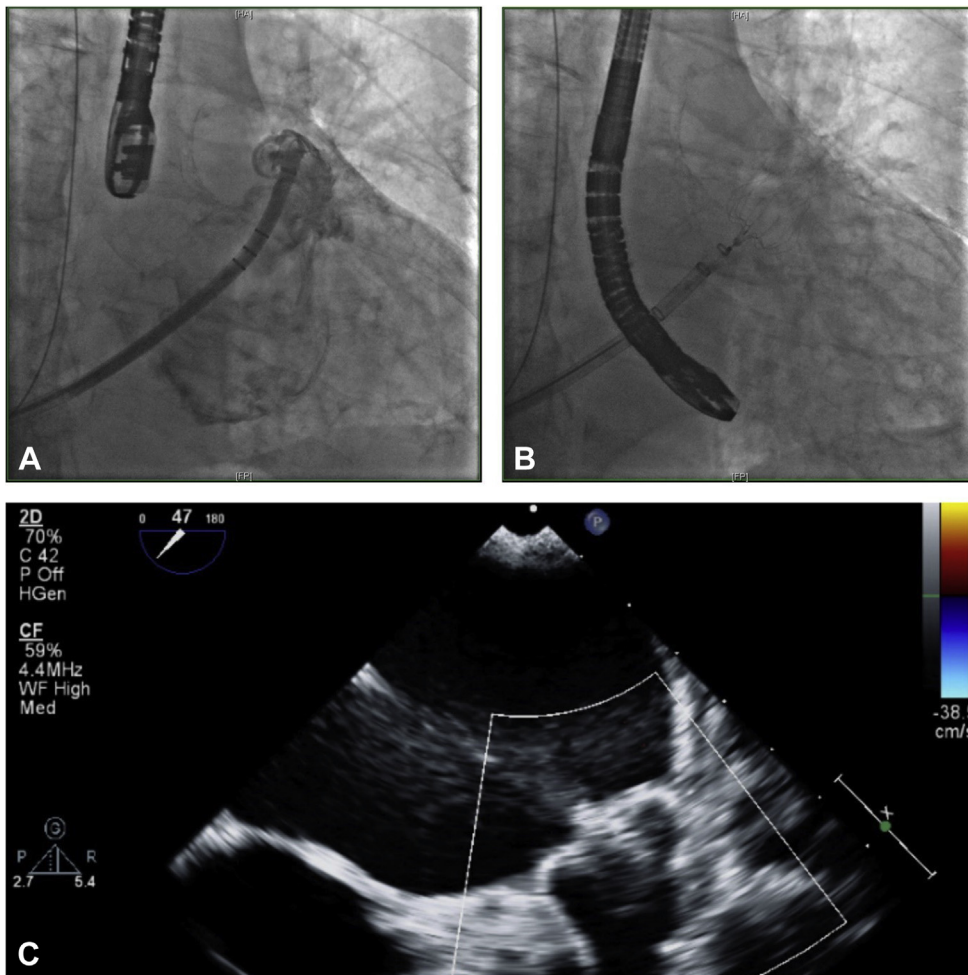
Hepatic access and subsequent transseptal puncture. A: Fluoroscopic image showing placement of 0.32-inch Amplatzer SS wire (Boston Scientific, Marlborough, MA) in the hepatic vein. B: Transhepatic SL1 sheath (Abbott, Chicago, IL) advanced over wire to right atrium with a second safety wire in the superior vena cava. C: Transesophageal echocardiogram showing the position of the Baylis transseptal needle (Baylis Medical, Montreal, Canada) at the superior aspect of the atrial septum.
